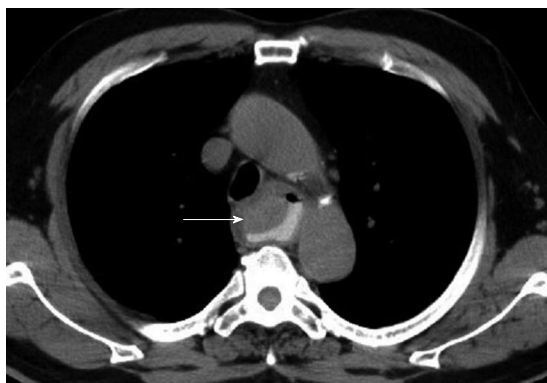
Computed tomography revealing a slight hyperdense tumor lesion (arrow) with a smooth surface over the upper esophagus, and no false lumen.
